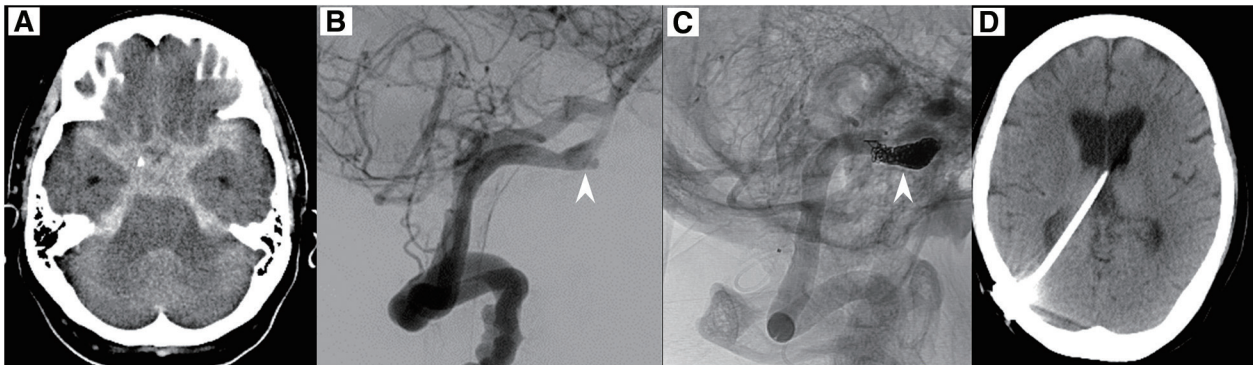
Intracranial imaging from admission to the last follow-up in the patient of Case 2. (A) A CT image of the patient taken on the first day of admission displays a diffuse subarachnoid hemorrhage. (B) DSA displaying right vertebral artery dissection (arrowhead). (C) DSA displaying an occluded parent artery, and coil embolization performed to the vertebral artery dissection (arrowhead). (D) CT displaying the ventriculoperitoneal shunt tube at the follow-up 3 years after the coil embolization
